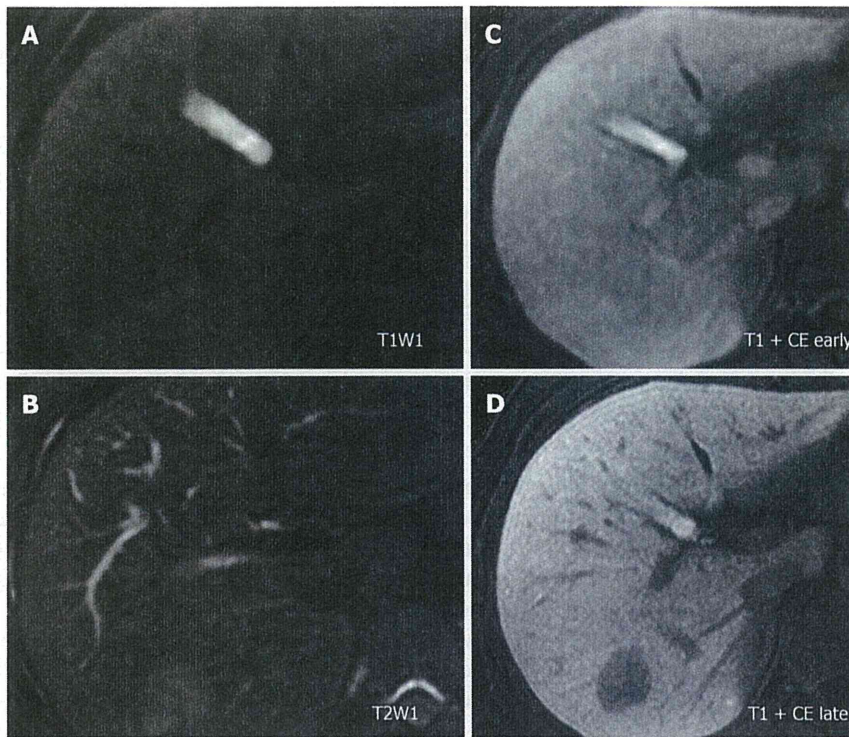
Magnetic resonance imaging of the tumor. A: The tumor showed an iso-intensity with the surrounding liver parenchyma on T1-weighted imaging; B: The tumor was visualized as a heterogeneous hyper-intense mass on T2-weighted imaging; C and D: After gadolinium ethoxybenzyl diethylenetriaminepentaacetic acid enhancement, the tumor was discernible in the arterial phase and was clearly detected as a hypo-intense lesion in the hepato-biliary phase on T1-weighted imaging. CE: Contrast enhanced.
